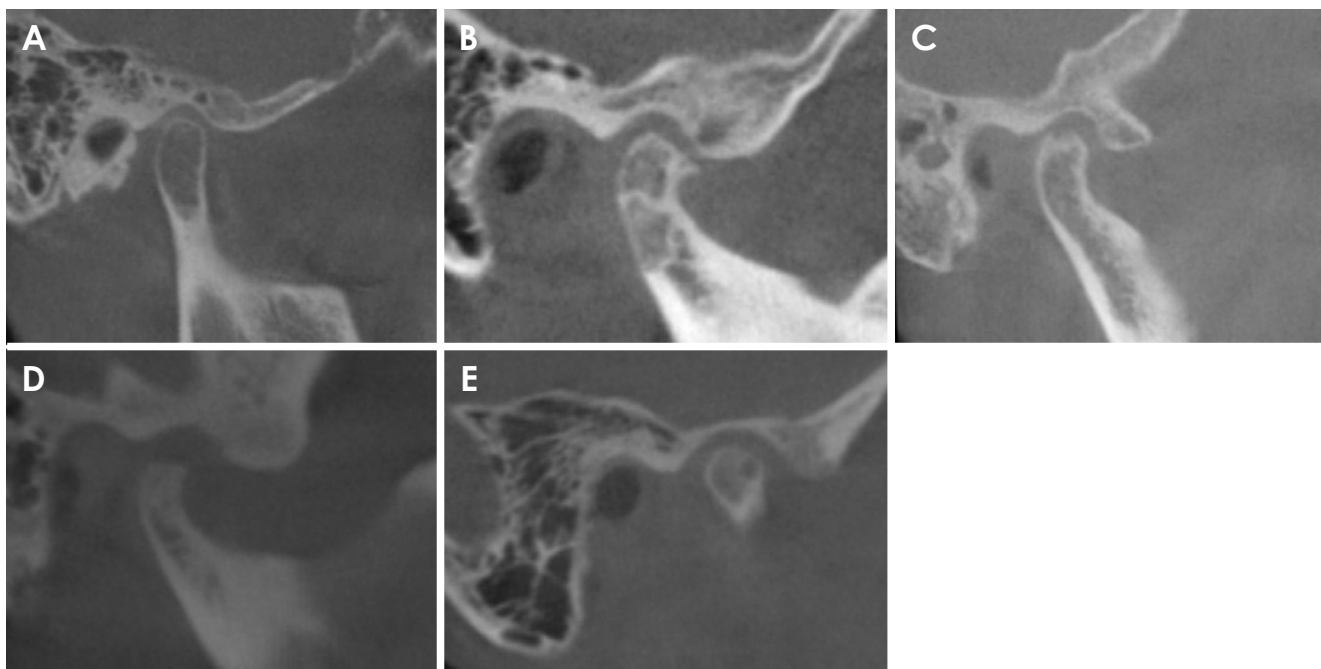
Sample cone-beam computed tomography images represent bony changes in the mandibular condyle, selected from subjects in this study. A. Normal state. B. Flattening and osteophyte. C. Erosion. D. Subchondral sclerosis. E. Subchondral pseudocyst.
